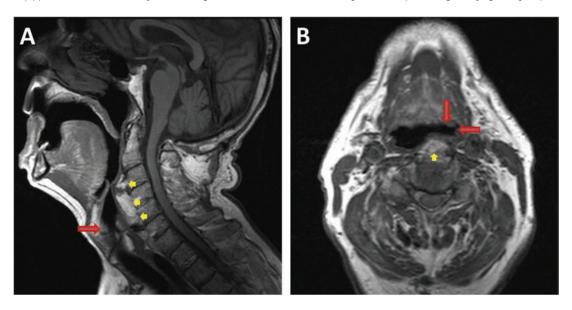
Cervical vertebrae osteophytes. (A) MRI sagittal T1 seguence showing cervical vertebrae osteophytes from C3 to C6 (yellow arrows) protrusing the posterior wall of the pharynx and reducing the supraglottic and glottic spaces (red arrow). (B) MRI axial T1 sequence showing a cervical vertebrae osteophyte (yellow arrow) protrusing the posterior wall of the pharynx and reducing the supraglottic space (red arrows).
